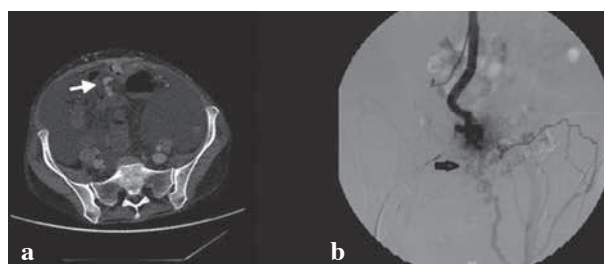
(a) Computed tomography demonstrated that common portosystemic collaterals on suprapubic area and submucosal ileal venous loops, widespread ascites between. (b) Venography imaging showed that hepatofugal flow, dilatation of ileal branch of superior mesenteric vein and subcutaneous collateral venous on the anterior abdominal wall.
